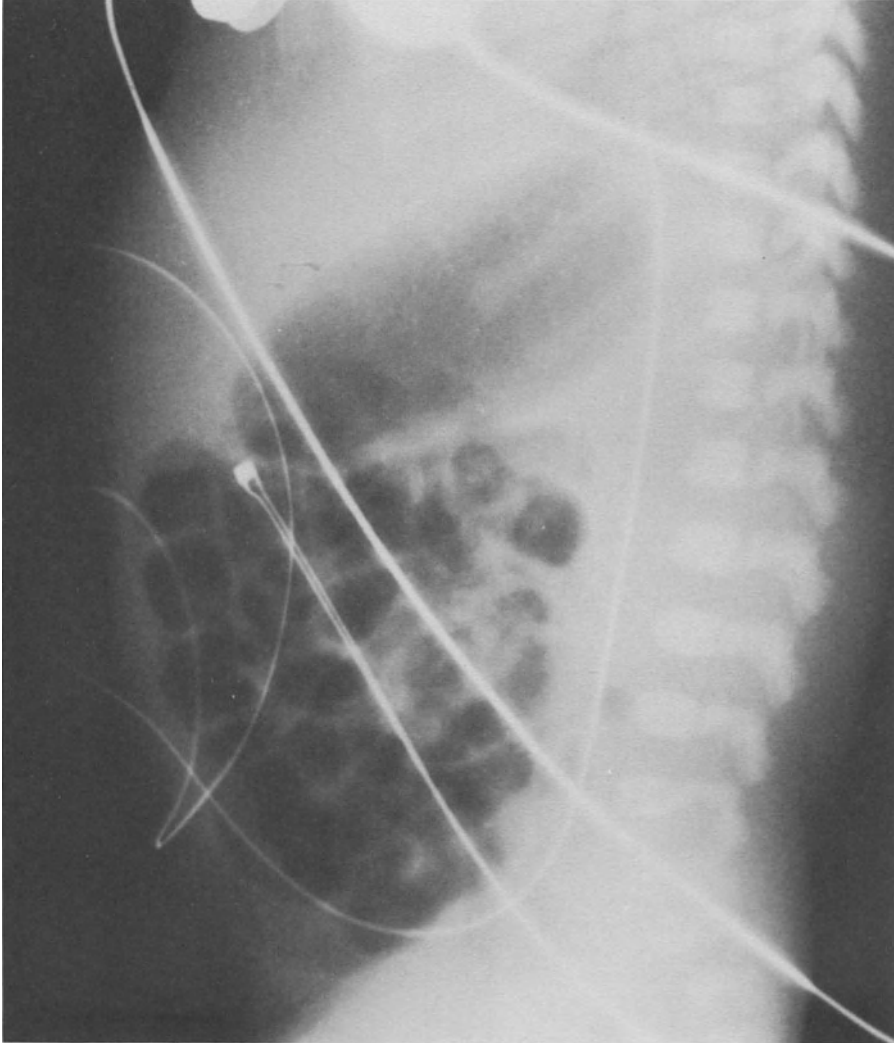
Lateral radiograph of a normal neonatal abdomen. The air-filled bowel loops project 2 to 3 centimeters anterior to the spine.
